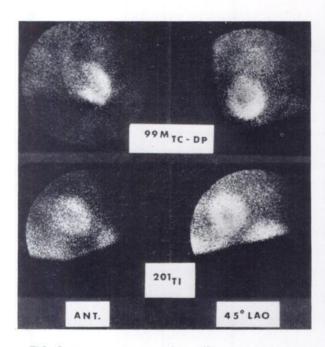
(Top) Anterior and 45° LAO <sup>90m</sup>Tc-diphosphonate scintigrams obtained 9 days after that shown in Fig. 1. (Bottom) Corresponding views obtained on same day with <sup>201</sup>TI.
